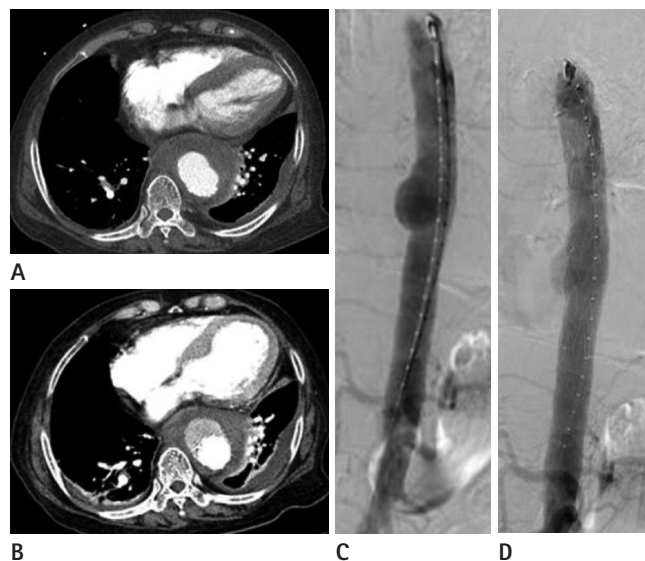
A-77-year-old woman with thoracic aortic aneurysm. A. CT angiography (CTA) image shows a 6.5-cm saccular aneurysm with discontinuous intima calcification in the descending thoracic aorta. B. Thoracic aortogram shows a 6.5-cm saccular aneurysm at the mid-thoracic level. C. Thoracic aortogram following thoracic endovascular aortic repair shows a delayed filling of the aneurysmal sac with blood flow from the left seventh intercostal artery, suggesting a type II endoleak. D. CTA shows an endoleak anterior to the stent-graft.
